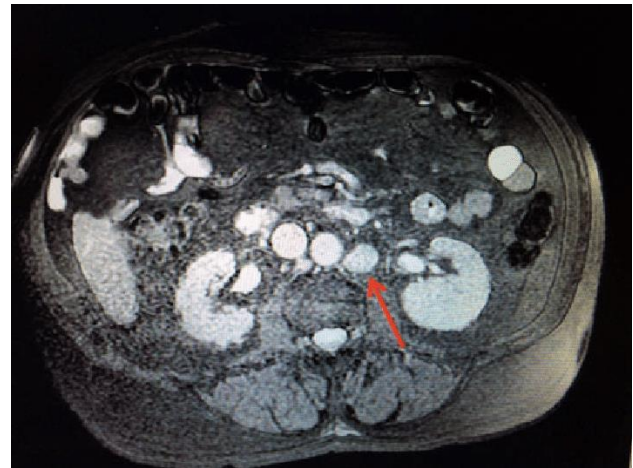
Para-aortic lymph node in magnetic resonance imaging
